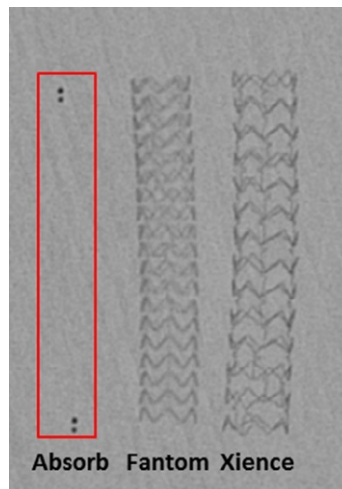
Radiopacity of coronary stents made from PLLA (Absorb), tyrosine-derived PC (Fantom), and cobalt-chromium (Xience). Abbott Vascular’s BVS has two platinum markers at the distal and proximal end of the BRS, but the whole scaffold cannot be visualized under X-ray. REVA Medical’s FANTOM has comparable radiopacity with the metallic Xience. Reproduced with permission from REVA Medical, Inc.
